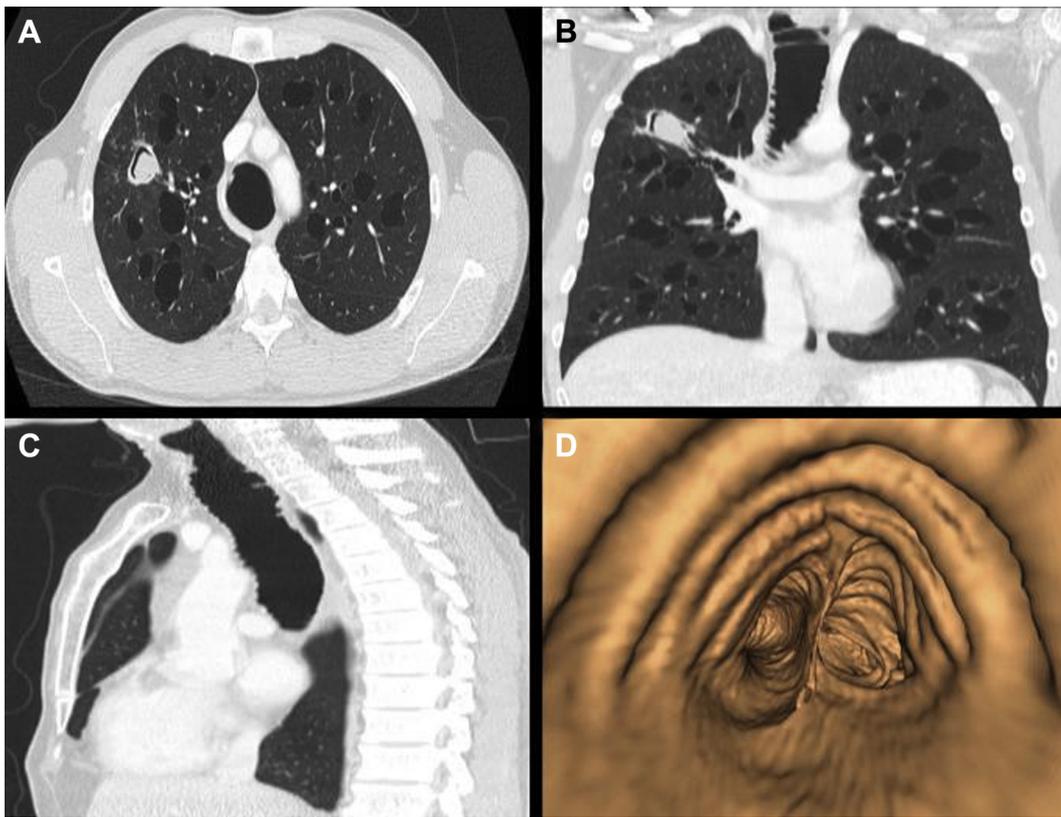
A, B, CT images of the lungs demonstrating multiple large “cystic cavities,” sparing the periphery of the lung parenchyma. A solid mass within one of the cystic spaces in the right upper lobe is noted, which was found to be *Aspergillus fumigatus*. C, Of note is the enlarged trachea, which is best visualized on the anteroposterior CT image. D, A virtual bronchoscopy image of the dilated tracheobronchial tree.
